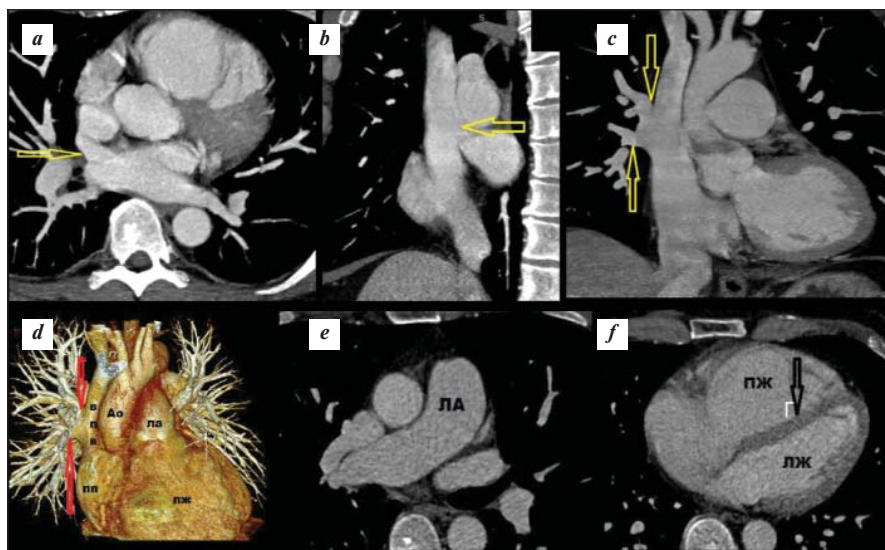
Contrast-enhanced CT of the heart of patient M.
